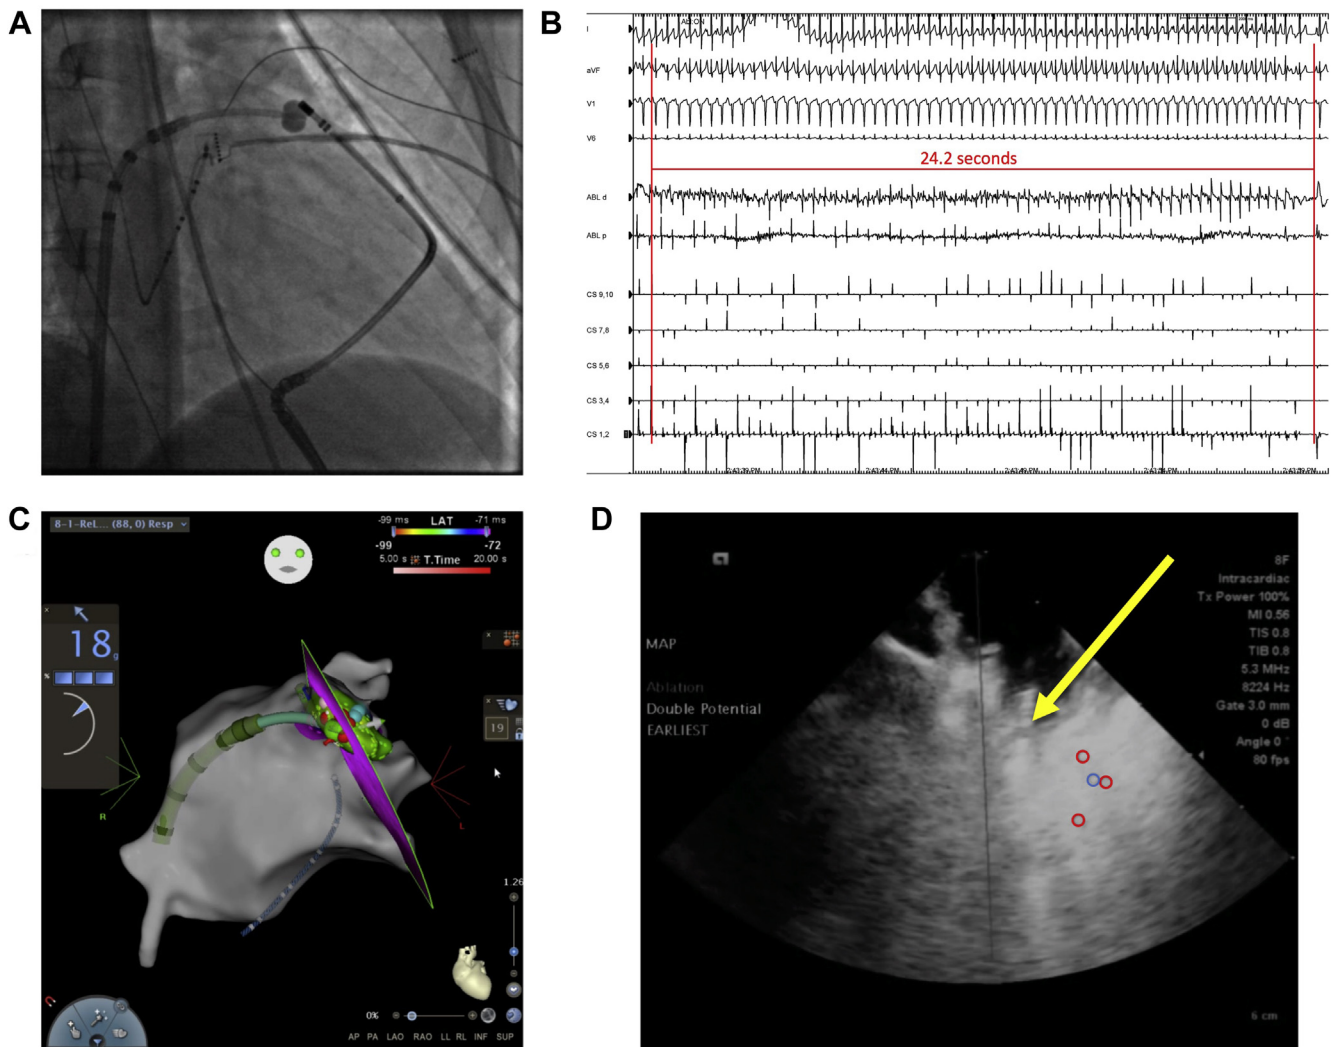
A: Fluoroscopic image in right anterior oblique view with 7F balloon-tipped Berman catheter (Teleflex Inc, Wayne, PA) placed within the distal left atrial appendage on the endocardial side for applying counter-pressure with the ablation catheter at the site of earliest epicardial activation. B: Successful ablation lesion from endocardial site with power titrated to 50 W with termination of tachycardia at 24.2 seconds. C: CARTOSOUND (Biosense Webster, Diamond Bar, CA) demonstrating ablation catheter at successful endocardial site. The ultrasound probe is in the pericardial space superior and posterior-medial to the left atrial appendage. D: Intracardiac percutaneous echocardiography image demonstrating ablation catheter tip (yellow arrow) within the distal left atrial appendage. Epicardial ablation lesions indicated with red open circles. Blue circle indicates annotation of an early mapping site on the epicardial side.
